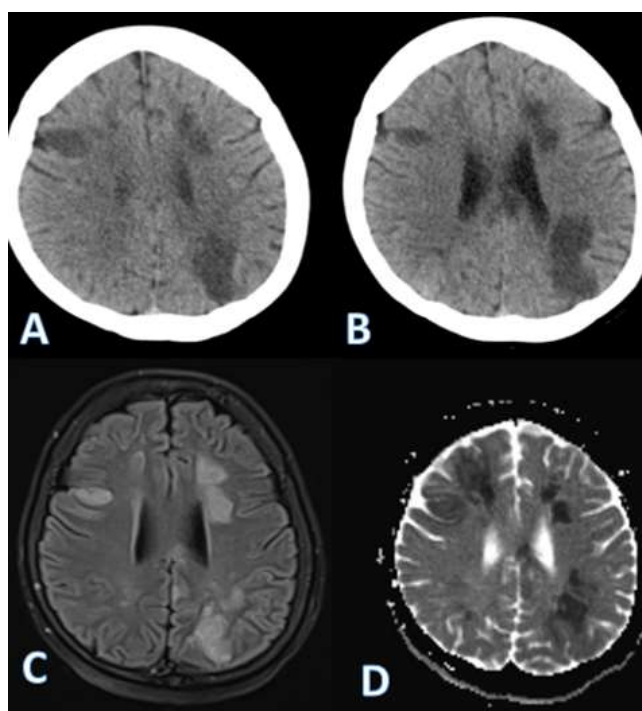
Axial Brain CT scan (A, B) showed hypodense cortical and subcortical wedge shape lesions suggestive of watershed infarctions. These findings are confirmed in DWI (C) and ADC (D) sequences.
